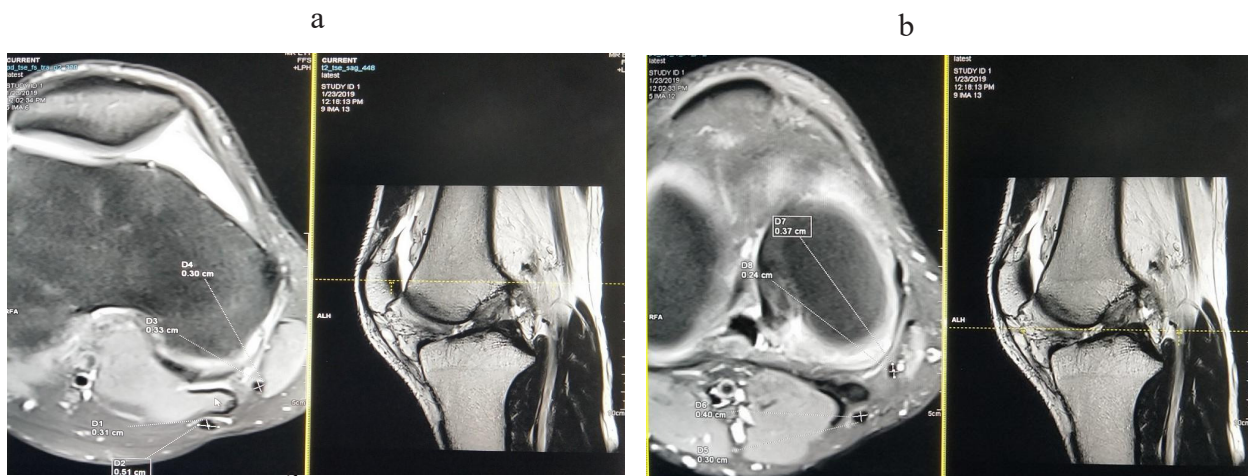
T2 weighted axial and sagittal MR images show the anteroposterior and mediolateral diameter of semitendinosus and gracilis at the level of (a) physal scar line level and (b) the joint line.
